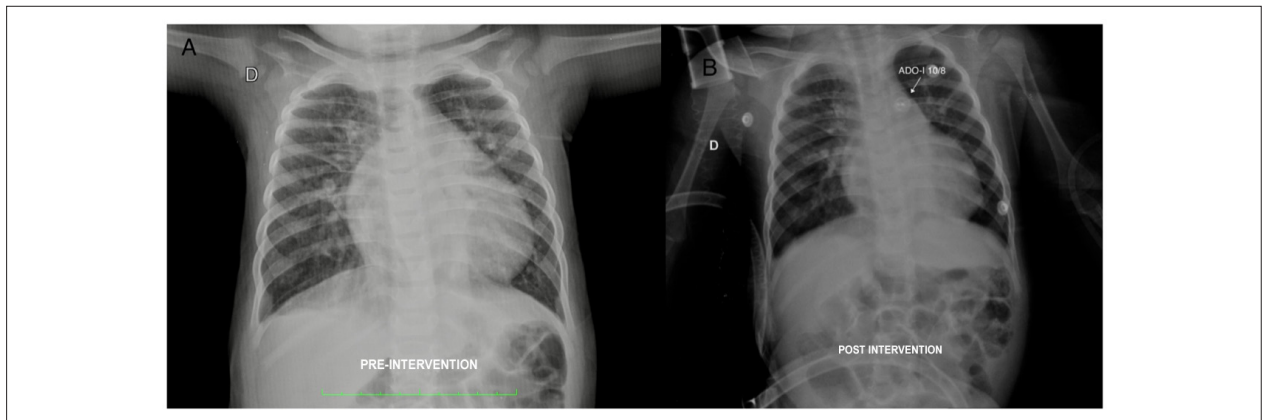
A) Pre-intervention chest x-ray. There is an overall increase in the cardiac silhouette, with prominence of the right atrium, left ventricle and vascular pedicle, in addition to the pulmonary vascular network. B) Chest X-ray approximately 8h after occlusion of the defect, showing the significant decrease in the cardiac volume, notably in the right atrium and the vascular pedicle, as well as a decrease in the pulmonary vascular network.
